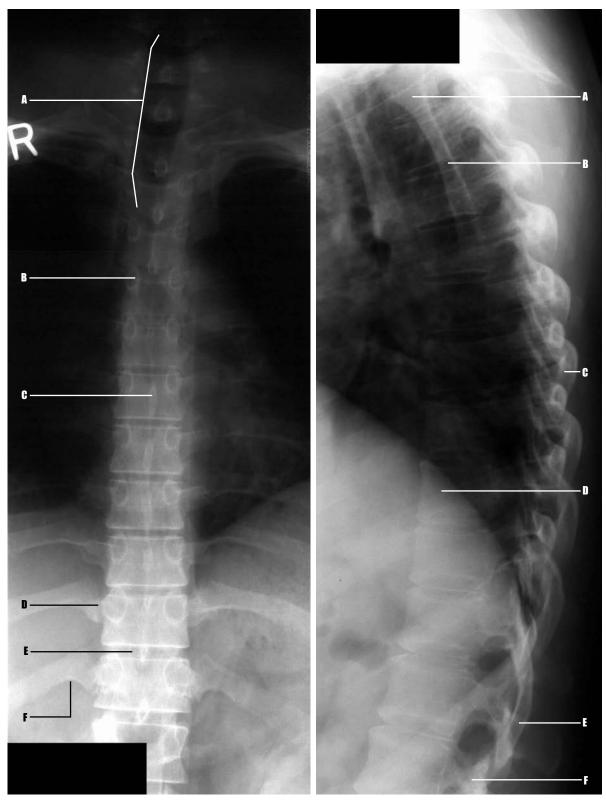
Adult patient, plain film radiograph, anteroposterior (AP) view of thoracic spine.
